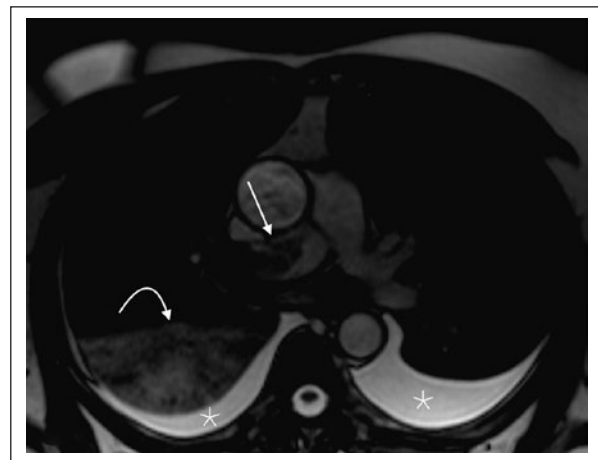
A Male patient with a history of pulmonary embolism. Magnetic resonance imaging, axial image in T2-weighted sequence. An opacification defect is observed in the right pulmonary artery (arrow) with acute angles to the wall of the vessel, conditioning its dilation in relation to acute pulmonary embolism (arrow). There are bilateral pleural effusions (asterisks) and a hyperintense area in the right lower lobe (curved arrow) related to the area of edema.
